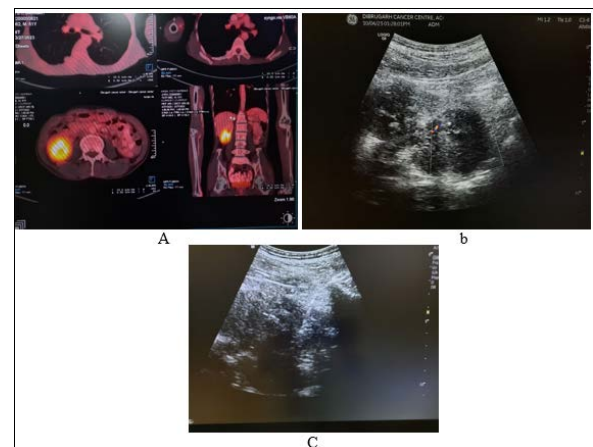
a, b, c: Showing FDG avid lesion in lower pole of right kidney on PET scan which was subsequently targeted using USG guidance and biopsy cores obtained. Prior study of PET scan images if available help in better planning of biopsy revealing central necrotic cores versus more FDG avid periphery which yield better tissue cores for sampling.
